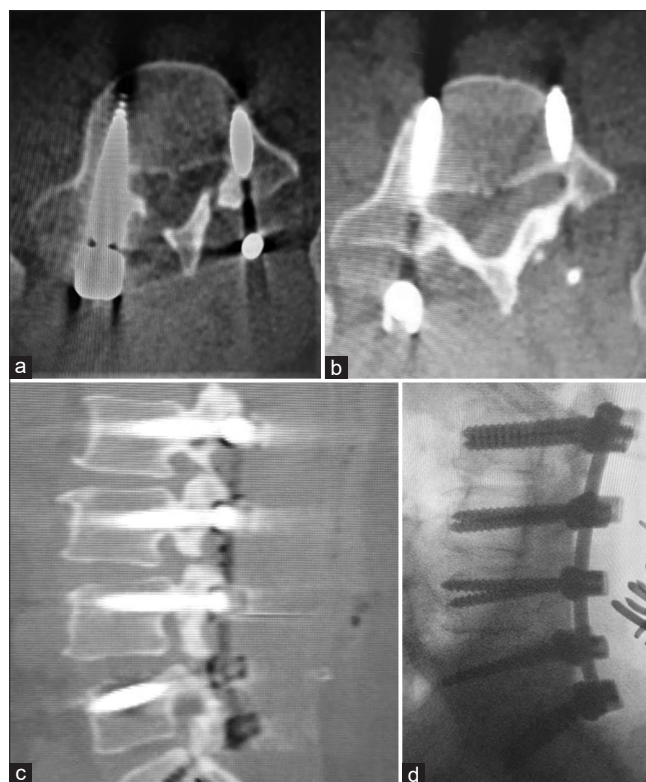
(a and b) Images of two axial cuts of computed tomography (CT) scan at L4 level in a case of transpedicle screws fixation from L1 to L5 due to lumbar canal stenosis with instability. Although the medial breach was located in the right pedicle, the patient was clinically silent. An anterior vertebral body breach with protrusion of the screws through cortical bone >4 mm at the left screw. (c) Sagittal reconstruction of CT scan with reasonable screws locations in the lateral view. (d) Intraoperative fluoroscopy image with good alignment of screws in the lateral plane.
